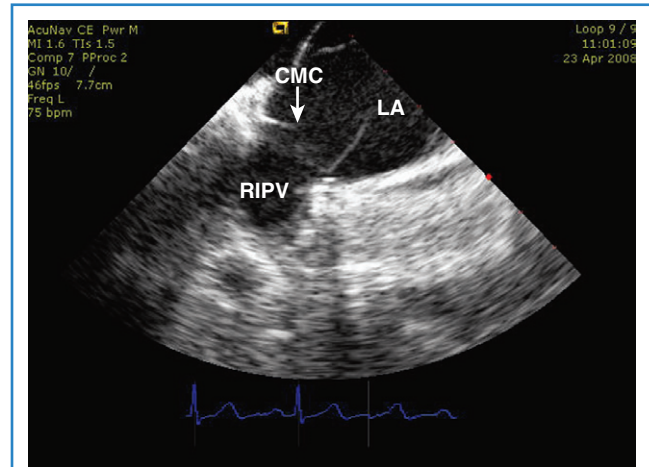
Intracardiac echocardiography image of the left atrium (LA) demonstrating the circular mapping catheter (CMC) at the antrum of the right inferior pulmonary vein (RIPV).
